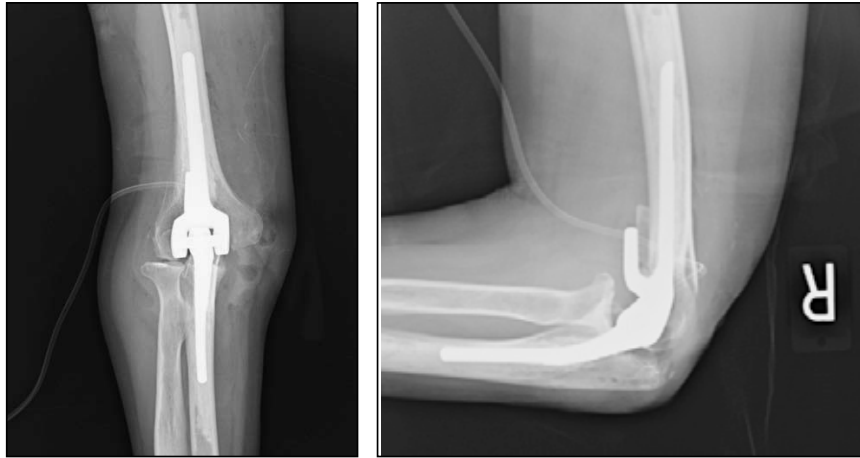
(left) and B (right). Postoperative radiographs of the right elbow in a patient after total elbow arthroplasty for endstage rheumatoid arthritis.
